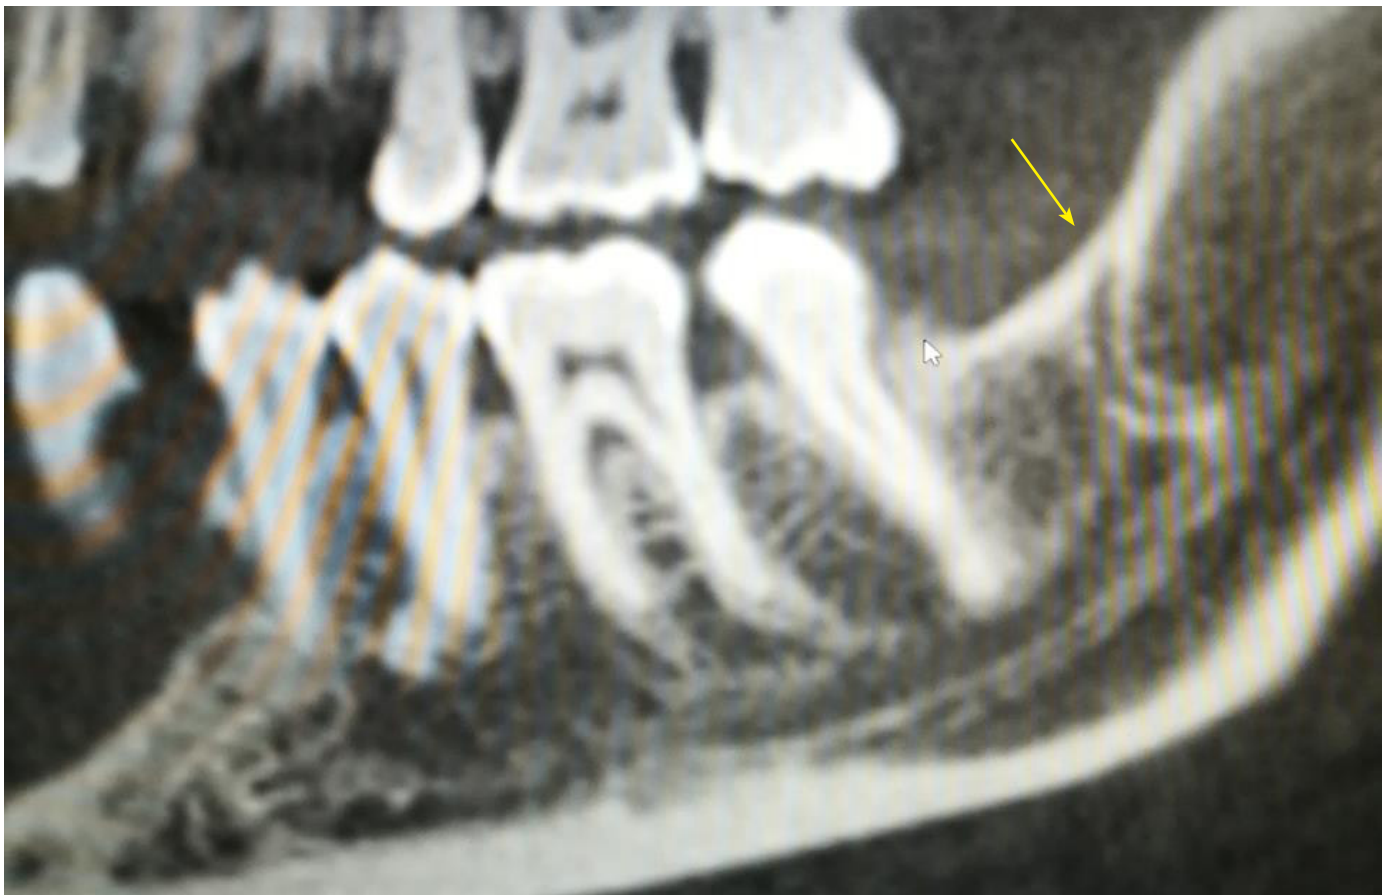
Cone beam computed tomography (CBCT) showing the anatomical variation of the bifid mandibular.
